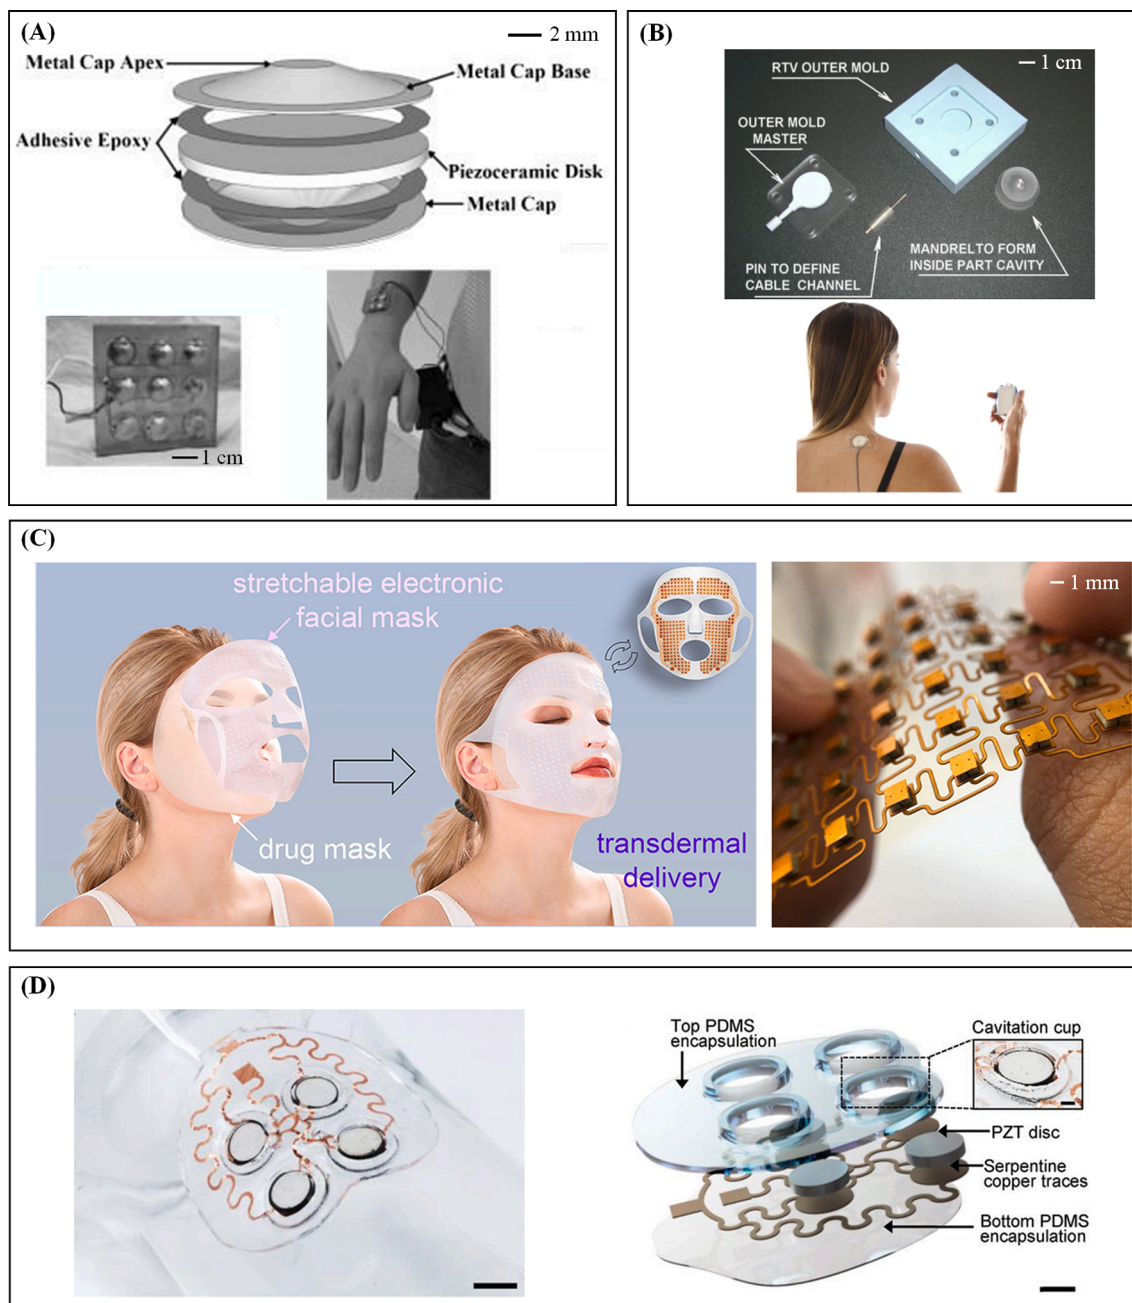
Wearable ultrasound devices. (A) A flexional transducer for a fully portable ultrasound applicator. (Adapted from [158], copyright 2012 Published by Elsevier B.V.). (B) A wearable self-applied therapeutic ultrasound device for chronic myofascial pain. (Adapted from [159], copyright 2013 World Federation for Ultrasound in Medicine & Biology. Published by Elsevier Inc.). (C) Stretchable electronic facial mask for sonophoresis. (Adapted from [160], copyright 2022 American Chemical Society). (D) A conformable ultrasound patch for cavitation-enhanced transdermal cosmetic delivery. (Adapted from [162], copyright 2023 The Authors).
